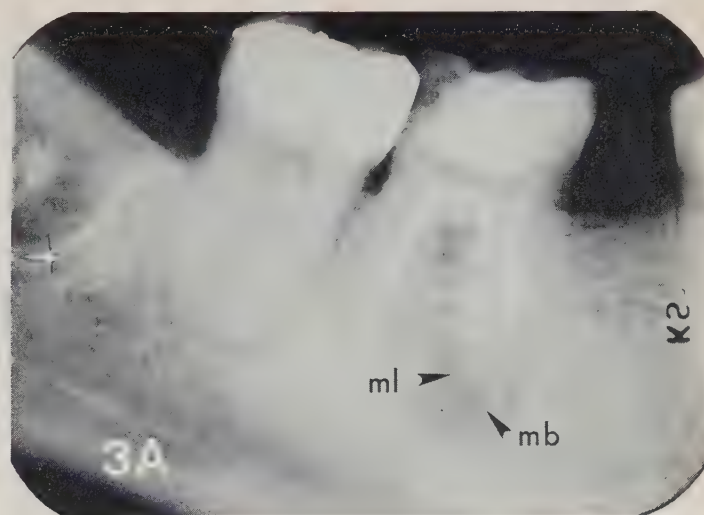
Pre-surgery radiograph of a mandibular molar exposed with a distal angulation. Note the periapical radiolucency and the separate mesiobuccal (mb) and mesiolingual (ml) apices and root canals.
